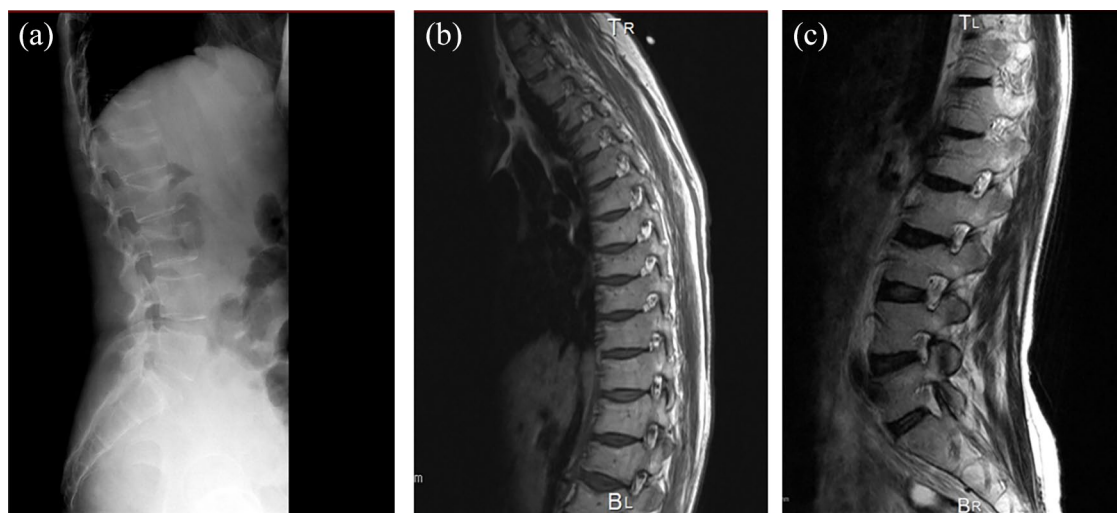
(a) Lateral view of the lumbar spine shows no new fractures. Magnetic resonance imaging findings for the thoracic and lumbar spine. (b) Thoracic spine T1-weighted image. (c) Lumbar spine T2-weighted image shows osteoporotic changes and compression fractures.
